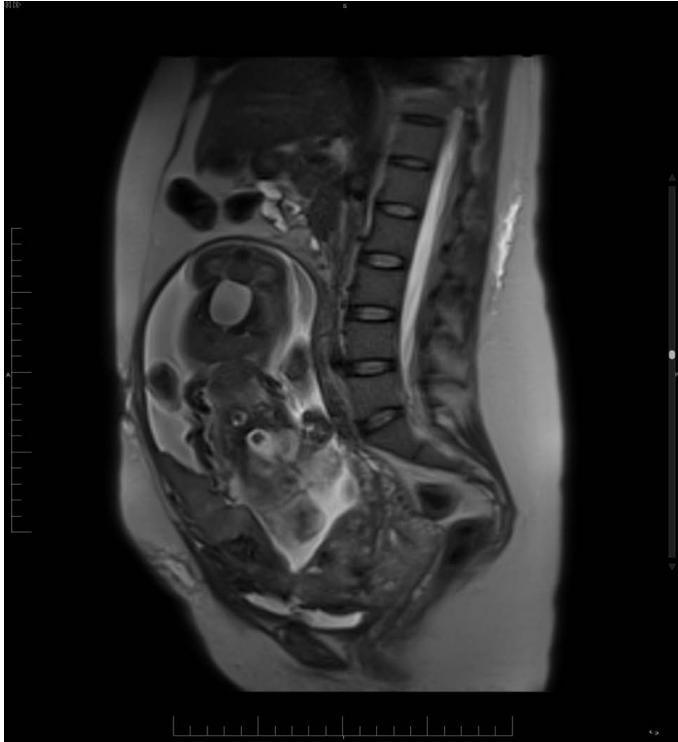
Saggital view abdominal MRI showing posteriorly located placenta that appears to completely cover the internal OS, indicating placenta previa with changes suggestive of placenta accreta and the possibility of placenta percreta.
